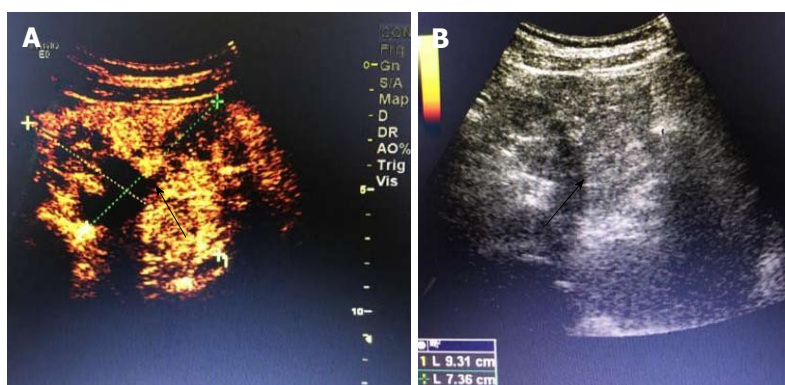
Findings of abdominal contrast-enhanced ultrasonography. A: Abdominal contrast-enhanced ultrasonography shows an abnormal morphology of the pancreas. A mass with inhomogeneous echo, sized about 9.3 cm × 7.2 cm, is found in the anterior pancreatic body; it has a well-defined border and regular shape, but the border with the parenchyma of pancreatic body and tail is poorly defined, with flocculent echo and strong spotty or patchy echo in the central part; B: Color Doppler flow imaging showed a few low-speed arteriovenous blood flow signals, whereas the echoes are homogeneous in the remaining parenchyma. The main pancreatic duct is not dilated. Black arrows indicate the mass.
